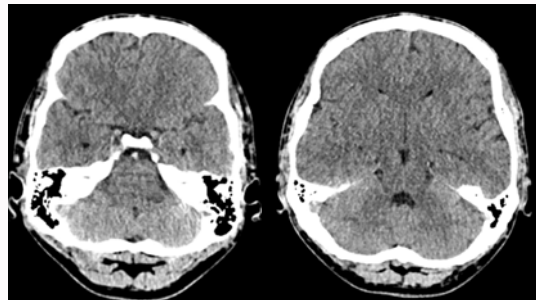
Plain CT Head: Showed hyper-dense basilar artery without any areas of established ischemia.
